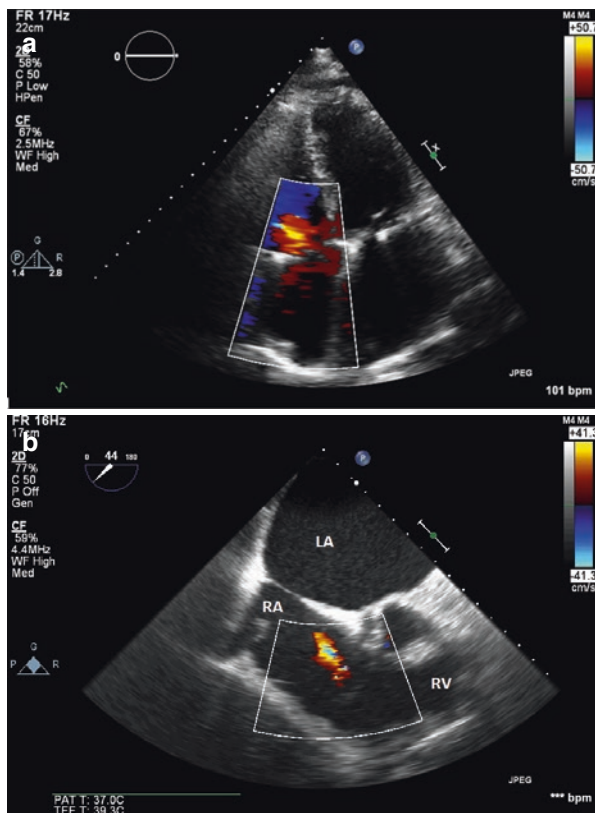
(a) TTE 4-chamber view with Doppler of the tricuspid valve during systole. None to trivial regurgitation is present. (b) Doppler TEE of the tricuspid valve also shows trivial tricuspid regurgitation
